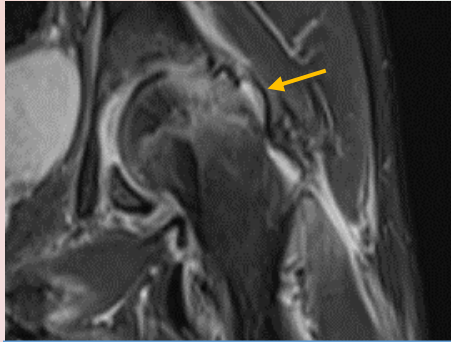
Coronal T2W MRI left hip showed similar hip effusion (arrow) and synovial thickening.
